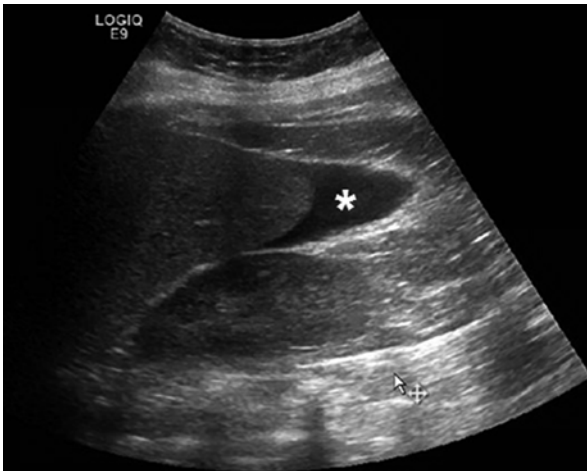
Hemoperitoneum by abdominal ultrasound. Abdominal ultrasound revealed hemoperitoneum, indicated with an asterisk (\*), extending from the pelvis to the liver edge
